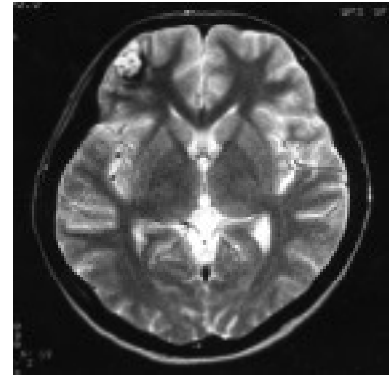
Previous axial T2-weighted MR image of same patient as Figs. 1-3a shows again the heterogeneous signal intensity lesion with a surrounding low signal rim. No surrounding parenchymal oedema is noted.
